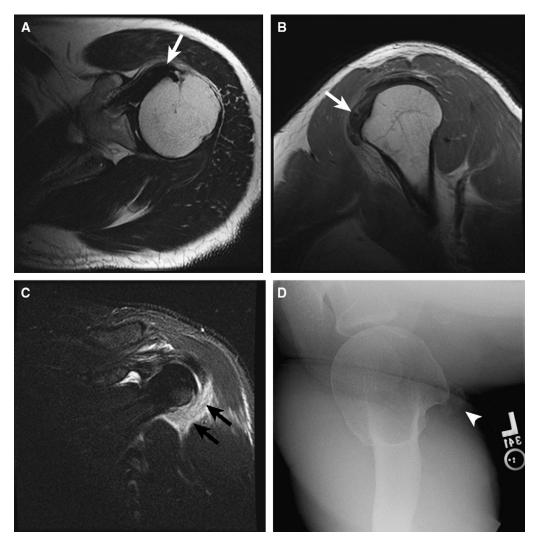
A 45-year-old man with acute left shoulder pain and limited range of motion. (A) Axial T2 and (B) sagittal oblique proton density MR images show ill-defined, globular, low-signal calcifications in the subscapularis tendon at its insertion onto the lesser tuberosity (white arrows). On the (C) coronal oblique T2 fat suppressed MR image, there is oedema in the soft tissues anterior to the humerus (black arrows). (D) An axillary view of the shoulder performed after the MRI confirms faint, amorphous calcifications adjacent to the lesser tuberosity (arrowhead).
